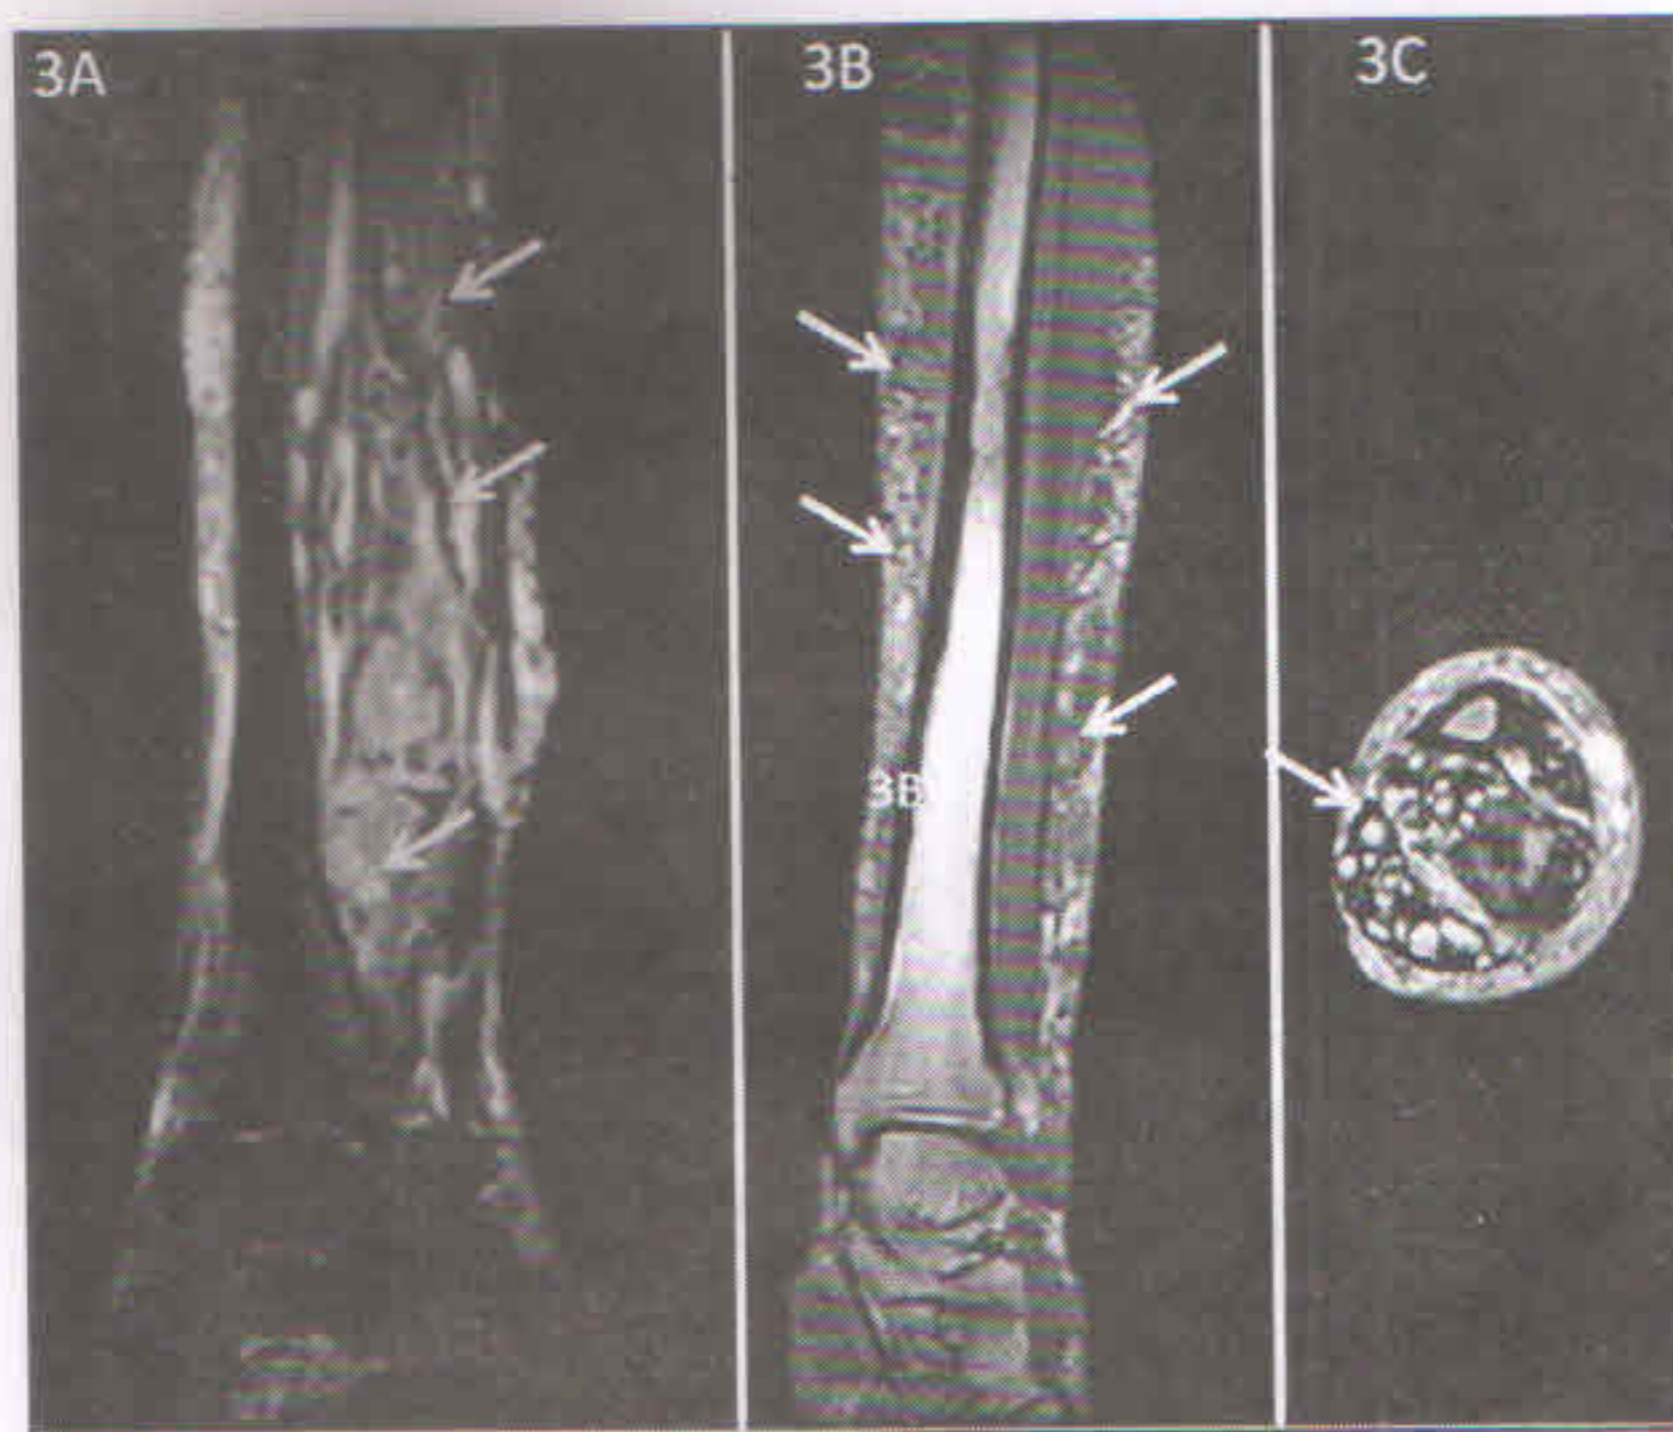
Sagittal TIRM (3A), coronal T1W (3B) and axial T2W (3C) MR images showing hypertrophy of soft tissues of left leg displaying heterogeneous signals hyper intense on T2 and hypo intense on T1WIs. Multiple abnormal vascular channels (thin white arrow) with T2 hyper intensities & T1 hypo intensities suggestive of varicosities are seen within soft tissue of all compartments, subcutaneous tissues and in muscular planes.
